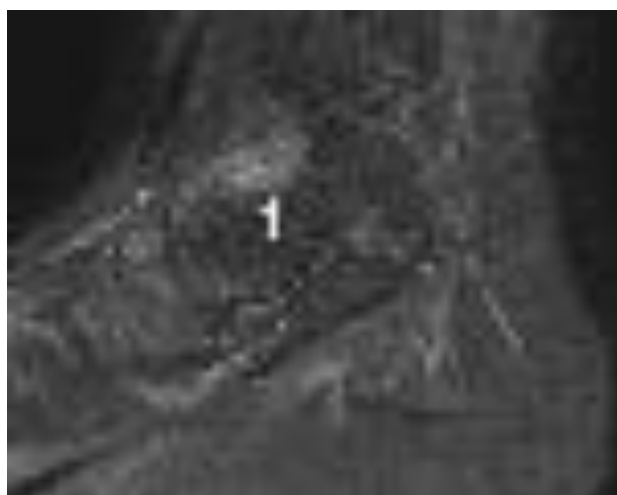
A 31-year-old female patient. (Sagittal STIR T2). In control Magnetic Resonance Imaging study done in 6th month following Radiofrequency ablation, there are post-operative changes in the lesion site (arrow). There is no edema in talus, effusion in joint space or synovial proliferation. STIR—Short tau inversion recovery.
